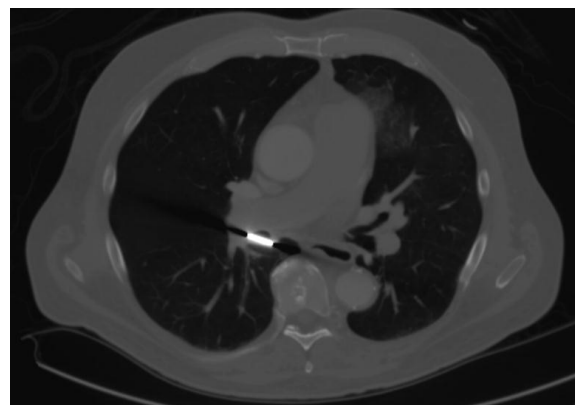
Computed tomography of the chest without contrast: A metallic foreign body lies in the right bronchus intermedius.
